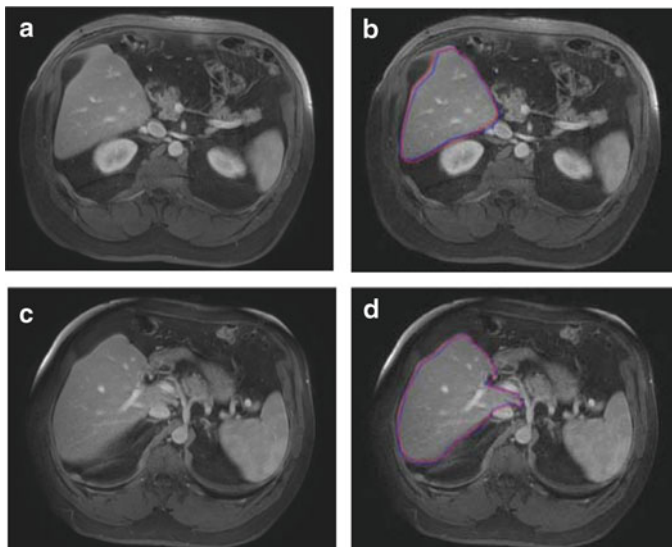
Comparisons of computerized liver extraction with “gold-standard” manual liver extraction for the case with a high accuracy (99.7 %). (a) Original axial MR image from the case. (b) Computerized liver extraction (*red contour*) and “gold-standard” manual liver extraction (*blue contour*). (c) Original axial MR image (different slice) from the same case. (d) Computerized liver extraction (*red contour*) and “gold-standard” manual liver extraction (*blue contour*)
